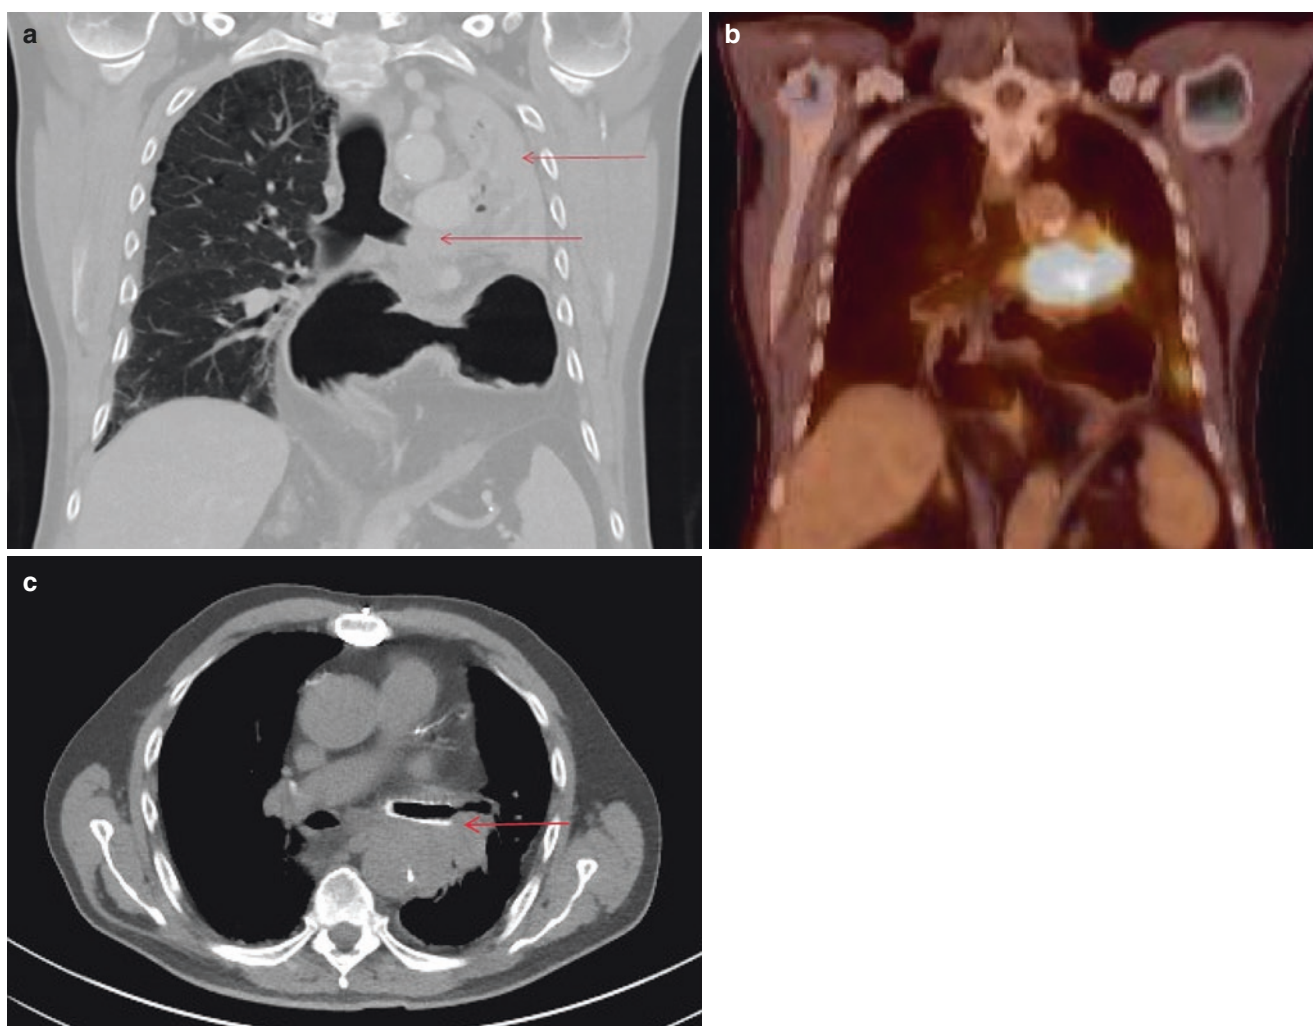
70-year-old male with mild hemoptysis and dyspnea with exertion. Computed tomography and a positron emission tomography (PET) scan showed a large left infrahilar mass causing complete obstruction of left mainstem bronchus and collapse of the left upper and lower lobes (a, *arrows*), showing a large hiatal hernia that was chronic
